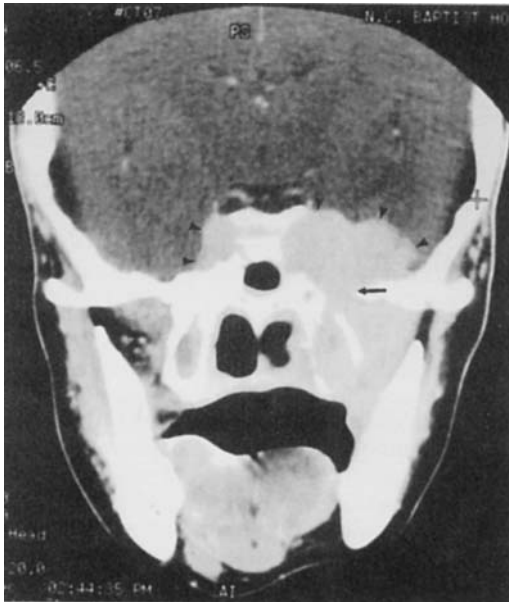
Perineural spread of adenoid cystic carcinoma (*soft palate*). Adenoid cystic carcinoma is notorious for perineural spread of tumor. Coronal postcontrast CT scan reveals tumor infiltration of the left infratemporal fossa (masticator space) and pterygopalatine fossa, with intracranial spread through the foramen ovale (*arrow*) into the left middle cranial fossa and bilateral cavernous sinuses (*arrowheads*).
